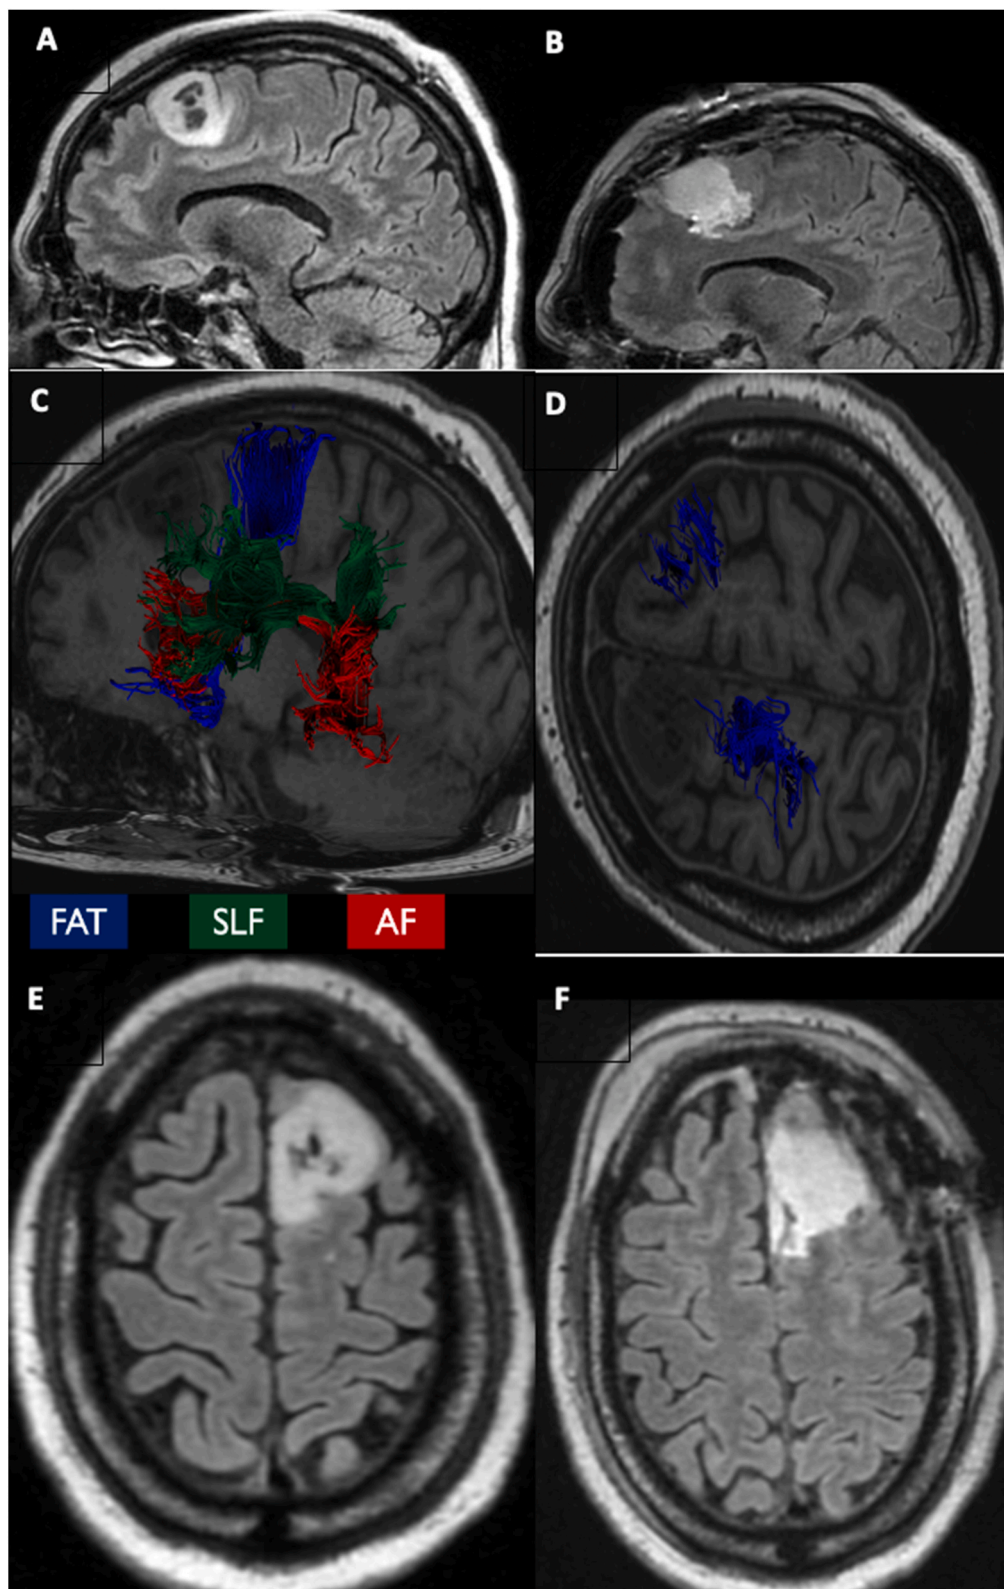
A. Pre-operative sagittal FLAIR MRI showing a low-grade glioma of the left supplementary motor area
